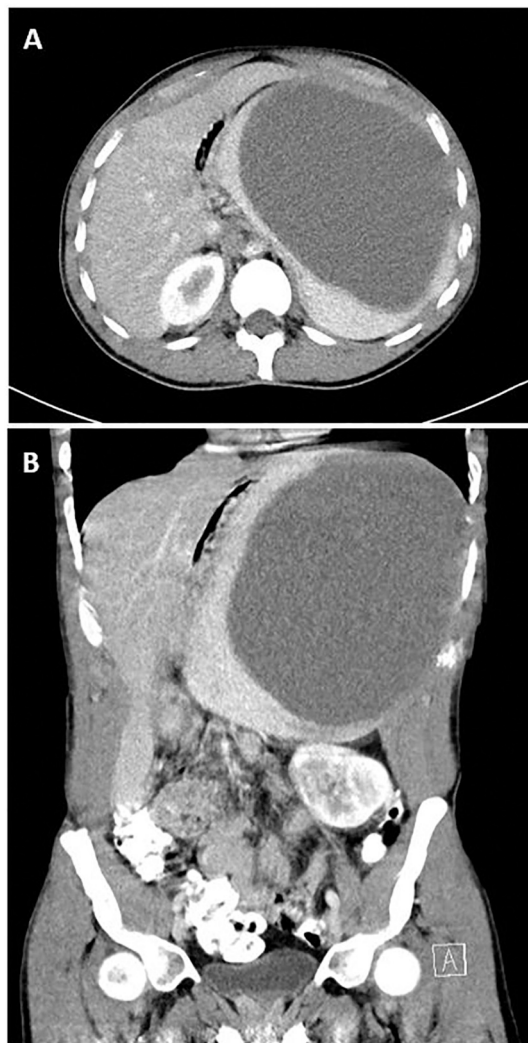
CT scans of the abdomen.
